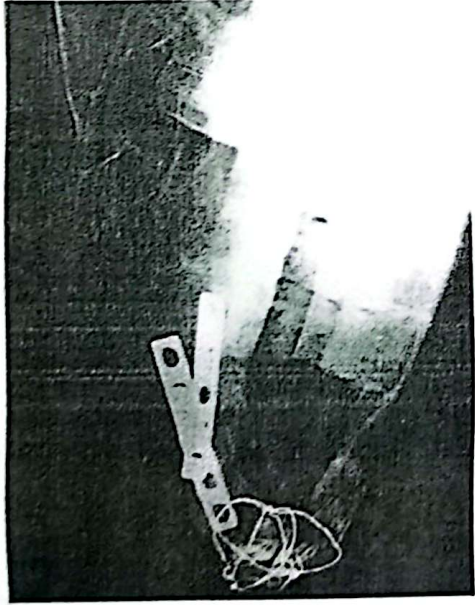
P.O. oblique lateral radiograph shows the position of DCP and dental interlock of the incisors with cerclage wire .
